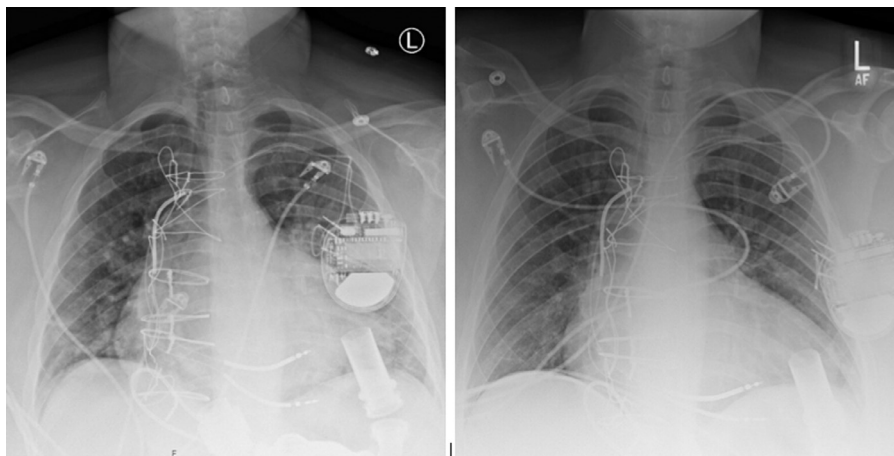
Posteroanterior chest radiographs obtained on day 1 (LEFT) and day 38 (RIGHT).
